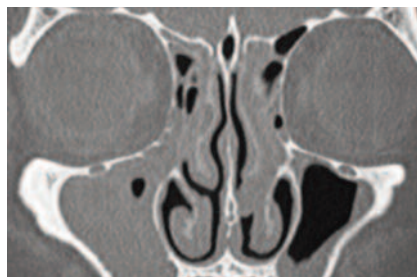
Coronal CT scan showing the classic signs of chronic rhinosinusitis. This patient needs urgent admission to hospital and aggressive treatment with parenteral antibiotics and possible surgical decompression.
